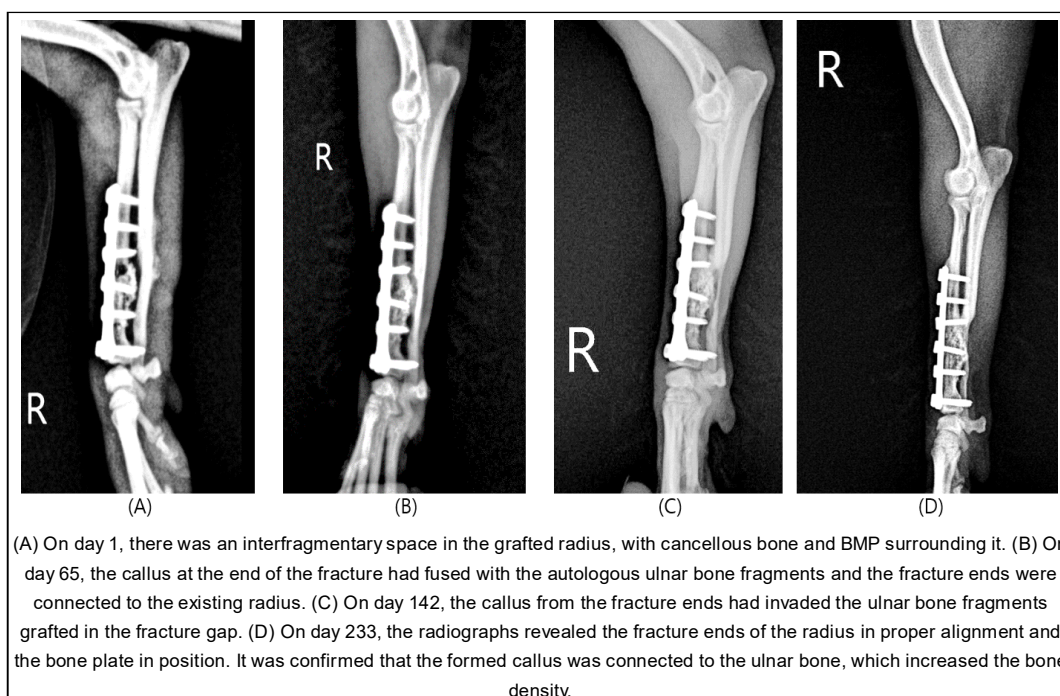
Sequential radiographs (lateral view) of the right radius and ulna.
